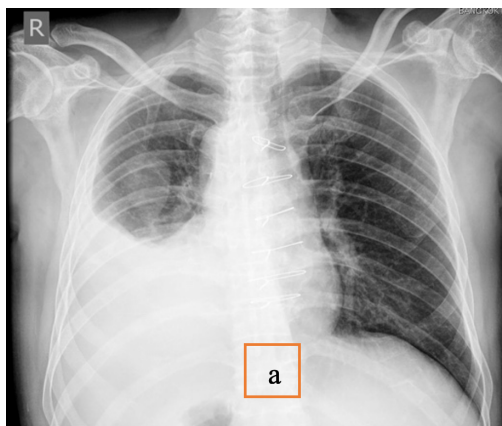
a. Chest X-ray image at the third postoperative week showing massive right pleural effusion. b. Chest X-ray image after percutaneous pleural fluid drainage.
